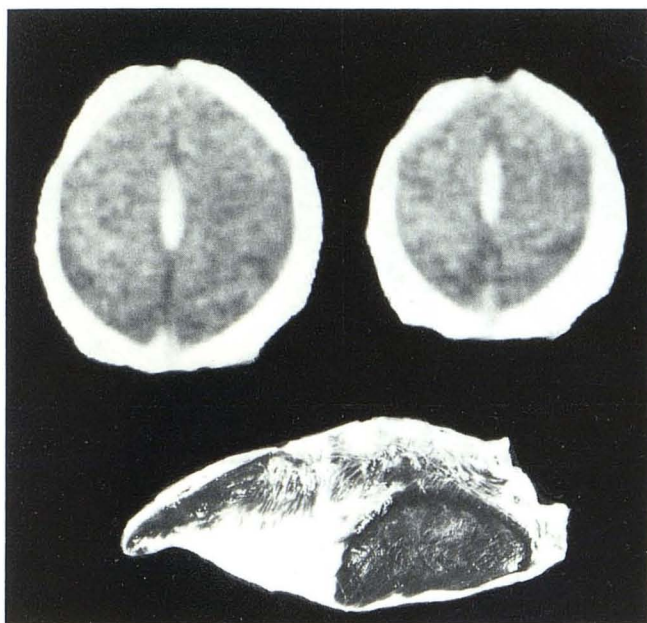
Intradural hemorrhage, premature neonate, 32 weeks, birth weight 1,830 g. Death at 2d day of life from complicated delivery and perinatal asphyxia. CT: circumscribed hyperdensity in interhemispheric fissure. Autopsy: broad intradural hematoma of falx (lateral view).
